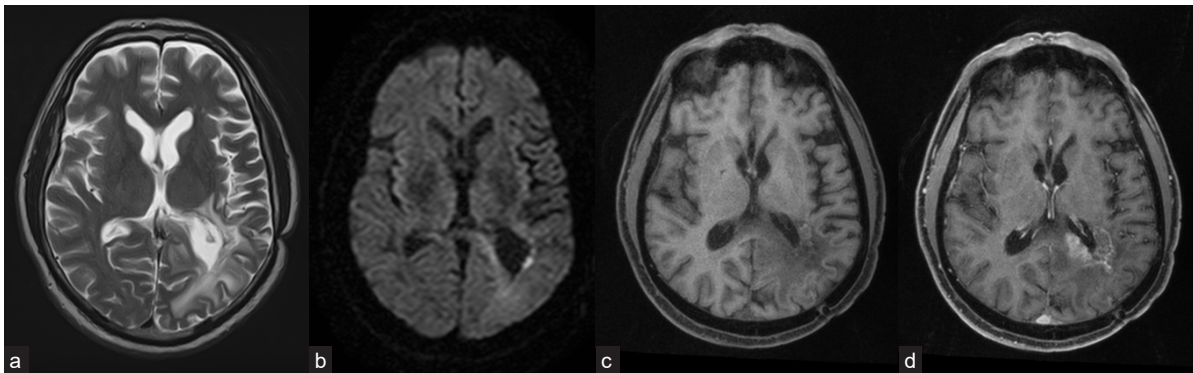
Contrast-enhanced MRI of the brain 14 months after sPDT (recurrence): (a) T2; (b) DWI (b 1000) – small area of diffusion restriction in the exposure area persists; (c) T1, before contrast; and (d) post-contrast T1 – small area of contrast substance accumulation and appearance of a new area of contrast substance accumulation with sizes 38 × 36 × 33 mm.
